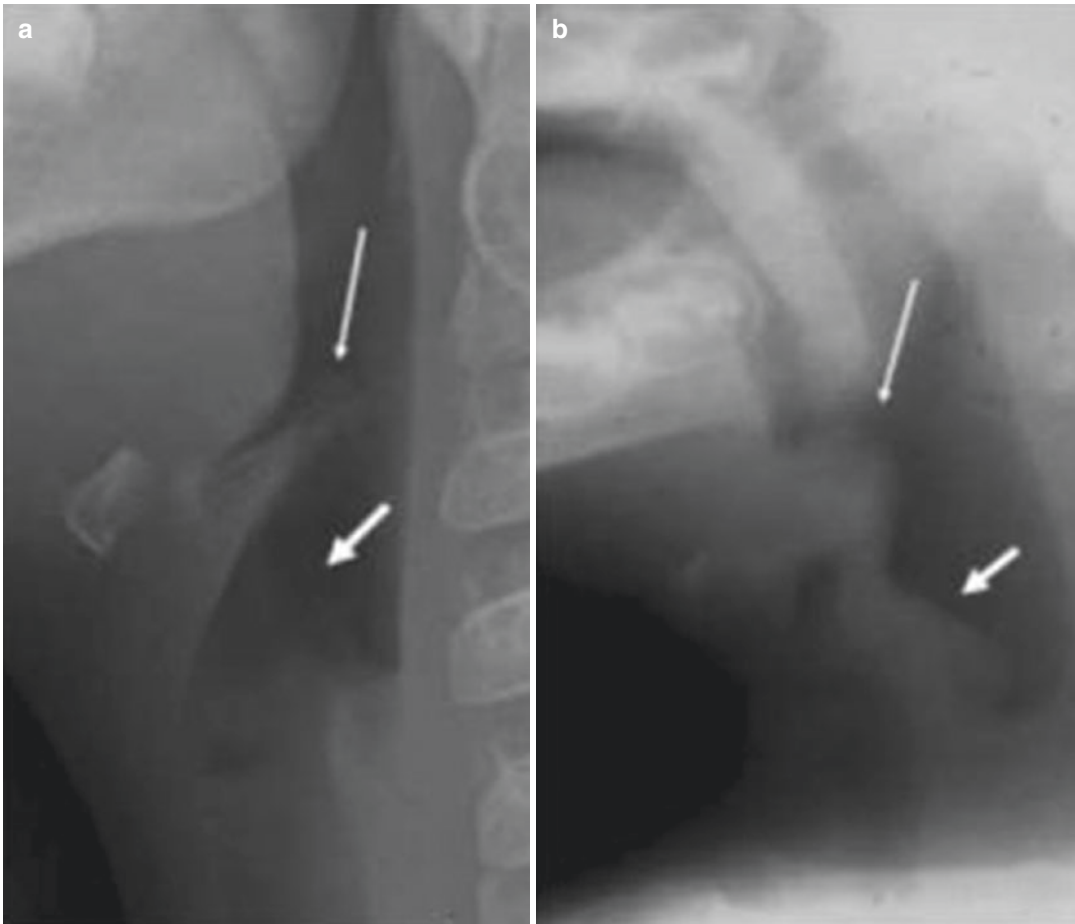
Acute epiglottitis. (a) Lateral neck x-ray of a 3-year-old patient, showing the epiglottis (*thin arrow*) and the aryepiglottic folds (*thick arrow*), both of normal size
